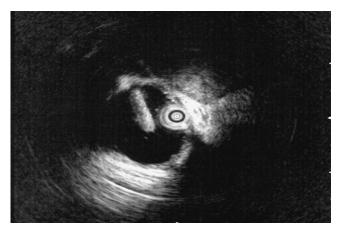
Common bile duct stone seen at intraductal ultrasonography.
